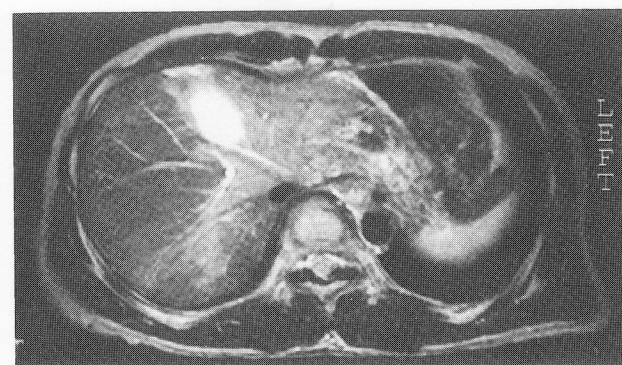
A 51-year-old man with confluent fibrosis in advanced cirrhosis. a: T1-weighted MR image shows wedge-shaped hypointensities in the periphery of the right hepatic lobe (stars). b: The regions are slightly hyperintense on T2-weighted images. c: Wedge-shaped decreases in ^{99m}Tc -GSA accumulation are shown on transaxial SPECT (arrowheads).
